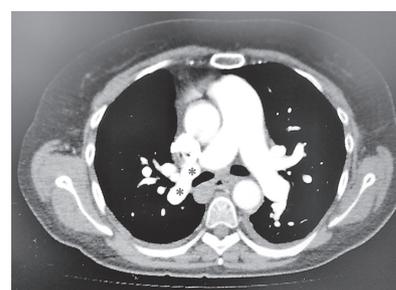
CT thorax showing right lung hypoplasia and the dilated and anomalous right pulmonary vein (red asterisks).
